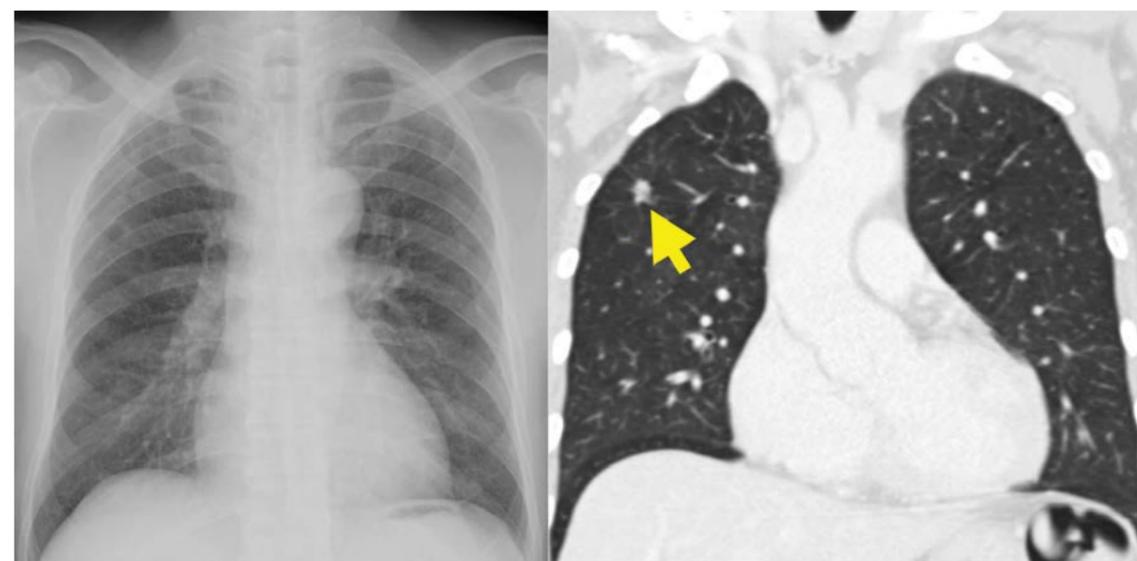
The right upper lobe pulmonary nodule (1 cm in size) is not visible on the radiograph (left) and only seen in the CT scan (right).
